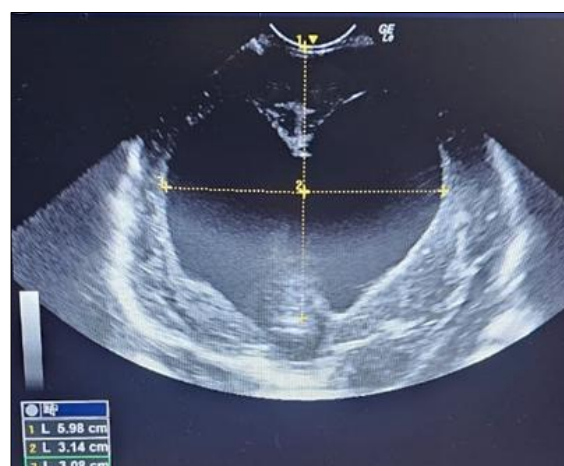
Neurosonogram demonstrating ventriculomegaly with left-side Levene index 31.4 mm and right-side index 30.8 mm
